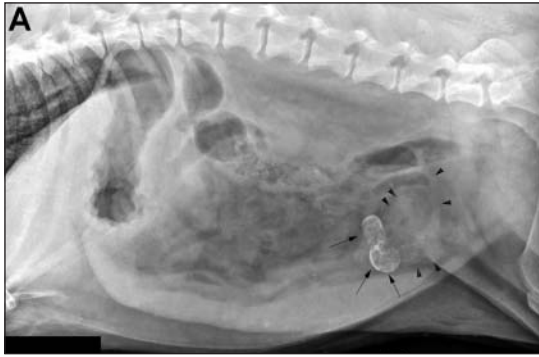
Same radiographic views as in Figure 1. Notice the oblong, opaque soft tissue mass (arrows) with a mineralized opaque rim in the right caudoventral portion of the abdomen. Caudal to the mass, a soft tissue mass has speckled mineralized-opaque foci (arrowheads) and appears to be continuous with a loop of small intestine.
